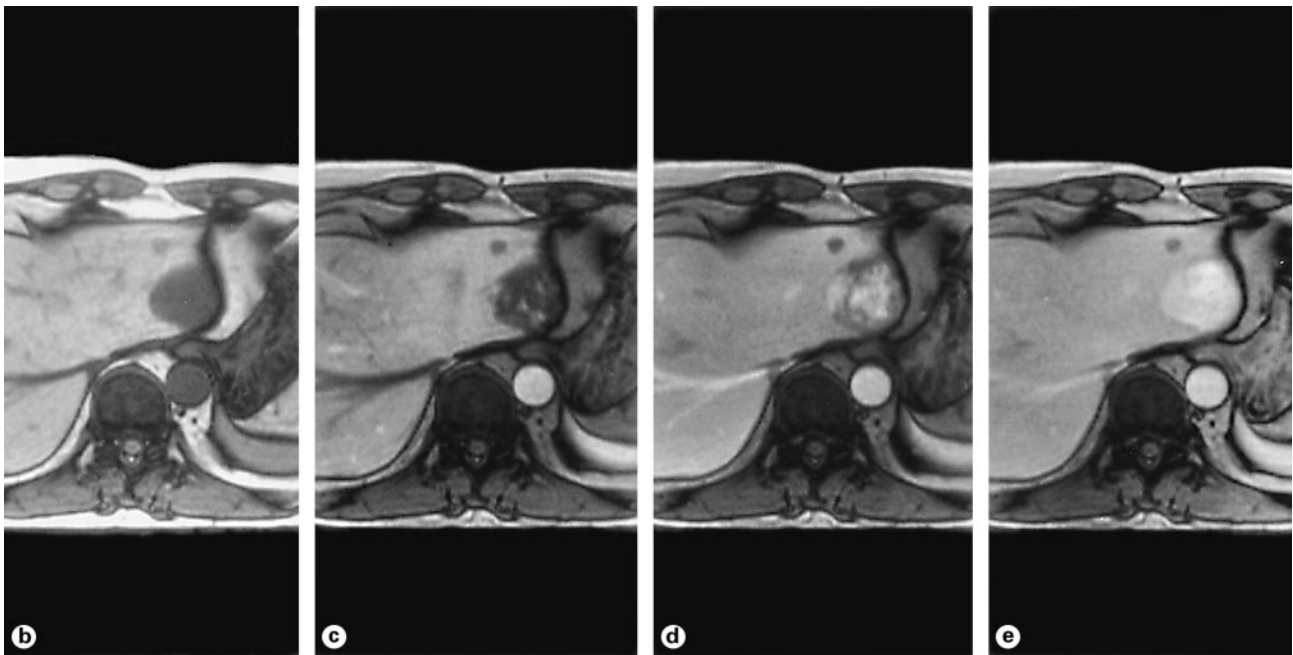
Cavernous hemangioma and cyst in a 40-year-old man. A hemangioma (arrow) is visualized as strong high intensity on T2-weighted MRI (SE, 2000/80) (a) and low intensity on T1-weighted image (b). A cyst (arrowhead) is also visualized as strong high intensity on T2-weighted image and low intensity on T1-weighted image. Arterial phase (c), portal venous phase (d), and equilibrium phase (e) images of dynamic MRI (2D gradient echo, 170/3.6/80) with intravenous Gd contrast medium injection show the hemangioma as the lesion with similar imaging patterns to dynamic CT. The cyst is not enhanced on dynamic MRI.
